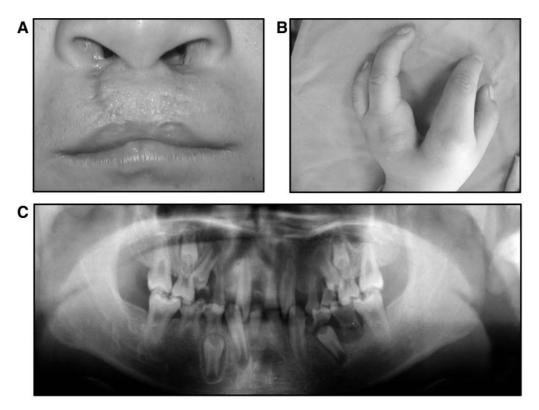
Typical clinical manifestations of the three affected subjects with EEC and LMS. (A) Patient 1 has bilateral complete cleft lip (repaired) and cleft palate. (B) Typical "lobster-claw" malformations on both hands and feet in patient 2. Note syndactyly of both toes with dystrophic nails. (C) Panoramic radiograph displayed multiple permanent teeth missing from both maxillary and mandibular arches in the 13-year-old girl (patient 3).
